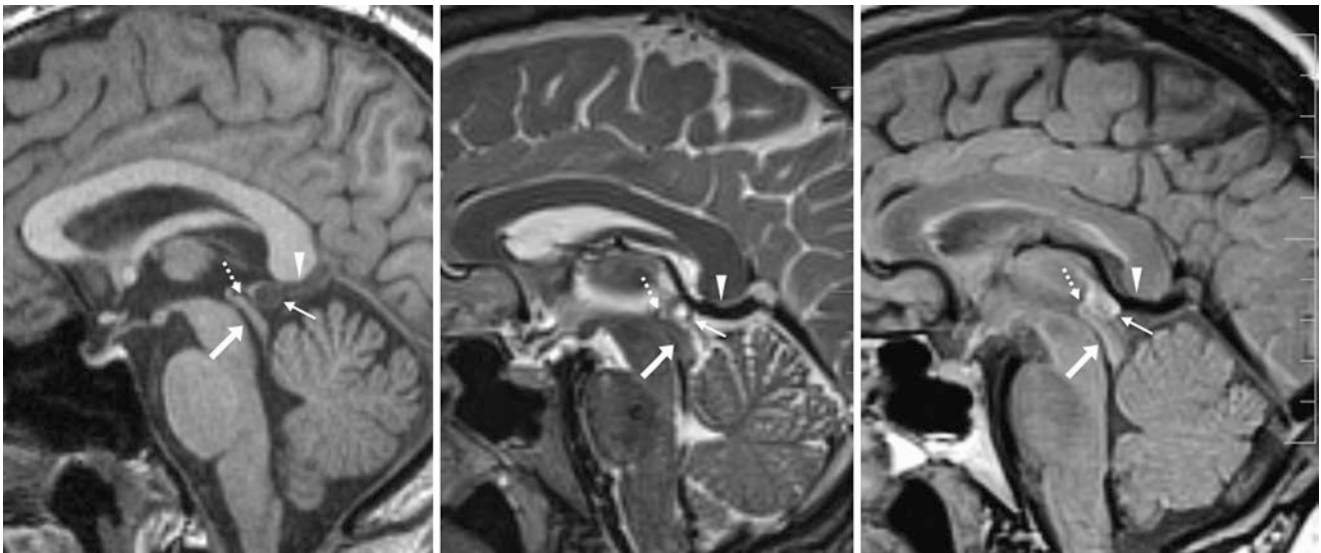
A 54-year-old patient who was asymptomatic underwent a 3 T research MRI. The patient had a tiny, 6-mm pineal cyst (*thin arrows*) posterior to the tectum (*dotted arrows*) without compression of the tectum or aqueduct (*larger arrows*; note the dark flow void indicating patency on T2WI and FLAIR) as shown on sagittal 1-mm thickness
